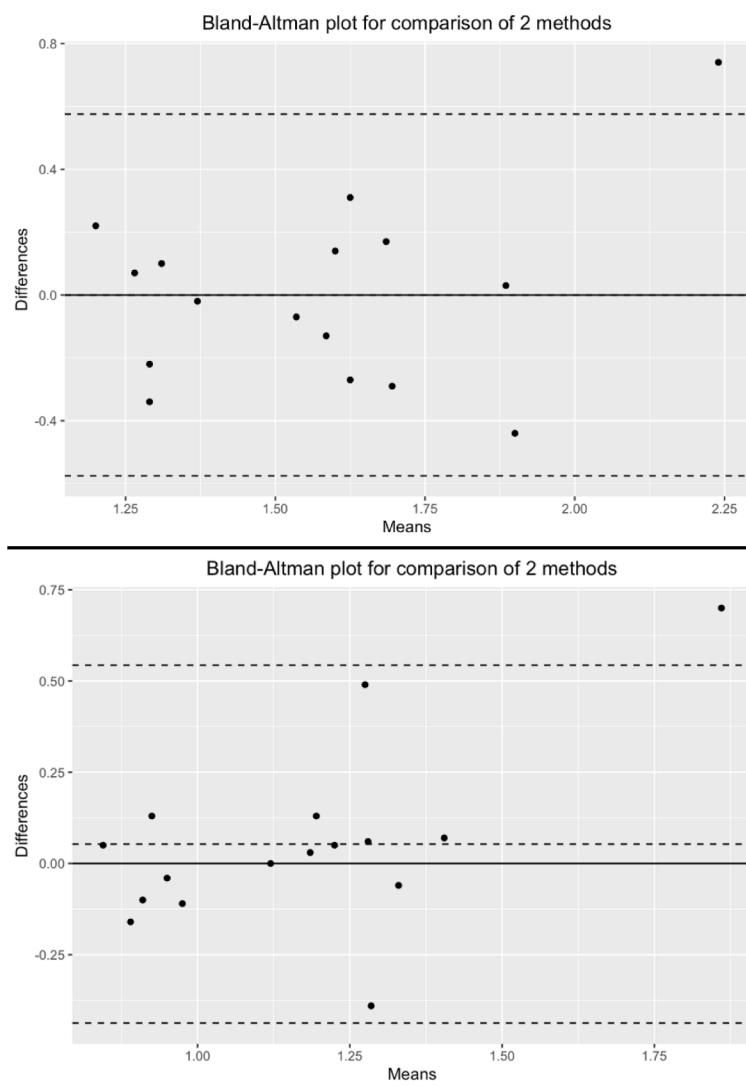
Bland-Altman analysis for the SUVmax and the SUVmean of the Aorta.
